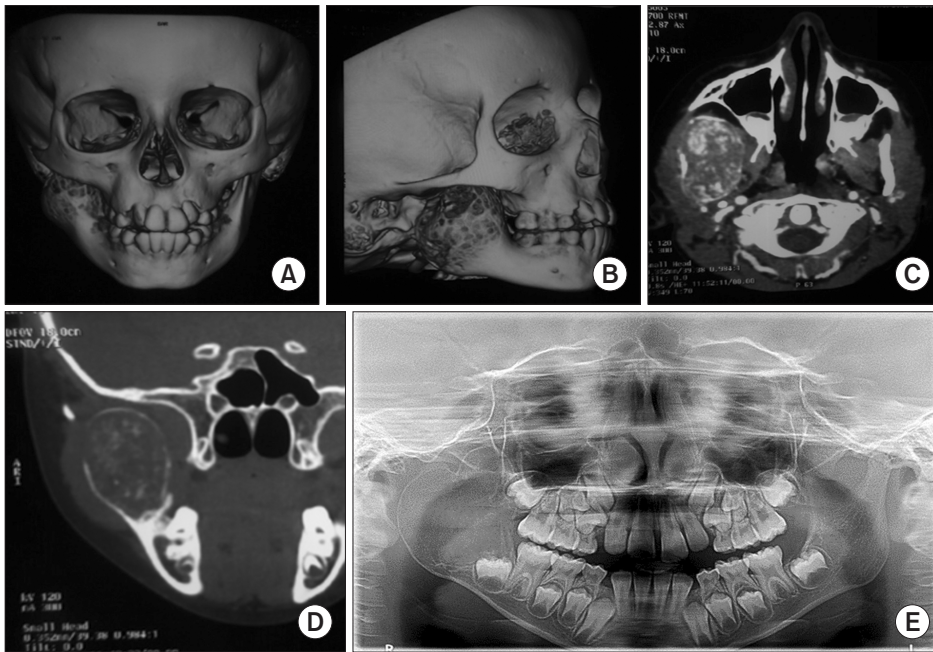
Right mandibular ramus osteoblastoma, extending from condyle and coronoid process to permanent lower right first molar: computed axial tomography (A and B: 3D reconstruction images, C: axial image, D: coronal image) and orthopantomography (E).
